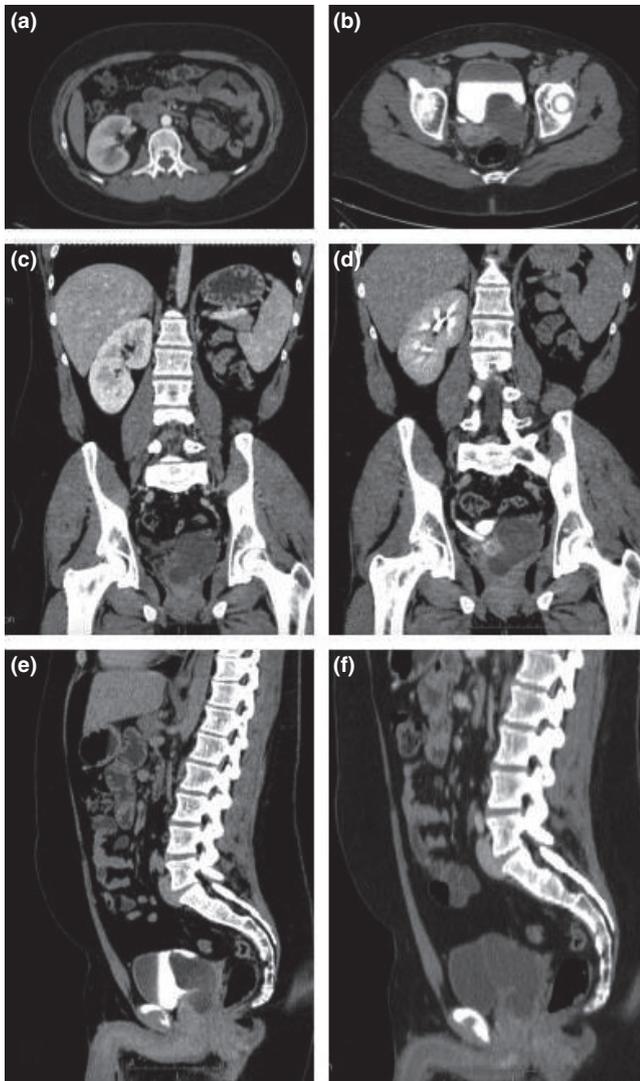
Abdominal contrast-enhanced CT: (a) left kidney agenesis; (b) left seminal vesicle that compress bladder and enlargement of the right seminal vesicle; (c, d) coronal CT scans showed ovoid hypodense mass of 65 × 46 millimetres with fluid content, that shapes the bladder and the left paramedian prostatic region, compatible with a left seminal vesicle pseudocyst; (e, f) sagittal CT images confirmed the left seminal vesicle pseudocyst and ipsilateral kidney agenesis
